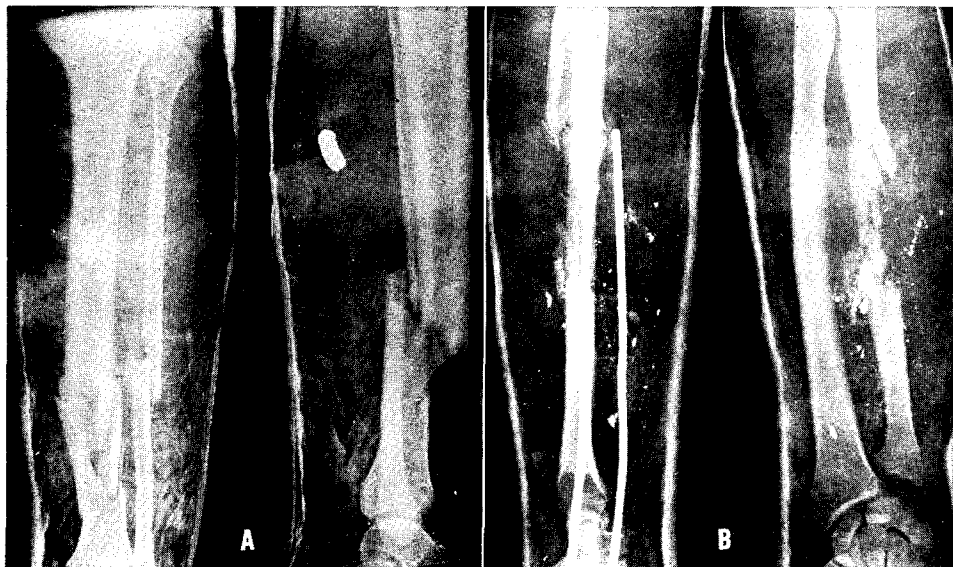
Roentgenograms of lower and upper extremities. A. Lower extremity wound caused by a U.S. hand grenade thrown by a Japanese. The grenade exploded 3 yards from the leg. The typical large fragment is shown. B. Fracture of the ulna and the usual small fragments characteristic of the Japanese hand grenade. The soldier was lying in a foxhole, and the grenade exploded almost in contact with the arm. Under these circumstances, there may be considerable brisance effect on the soft tissues.
